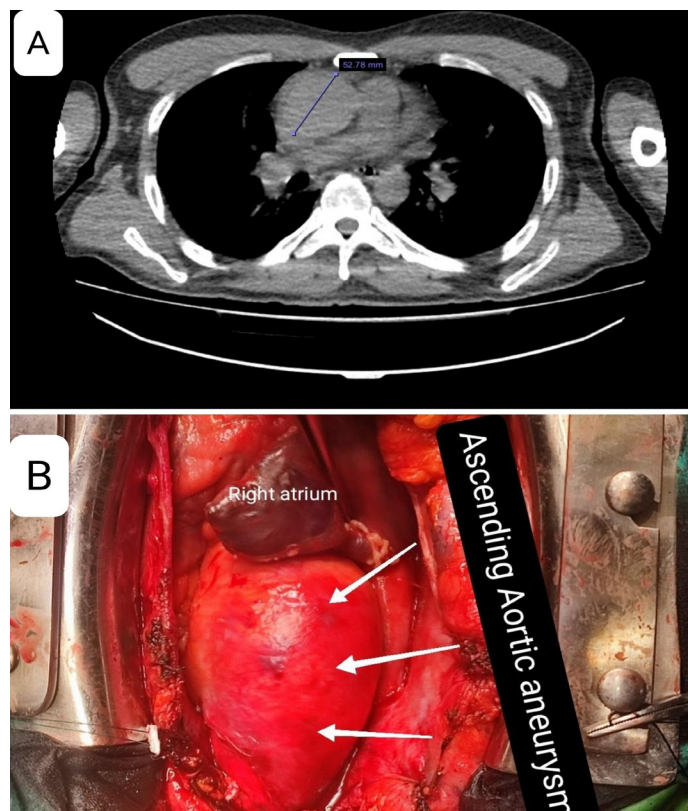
A. Preoperative computed tomographic image of the ascending aortic aneurysm. B. Intra-operative image that demonstrating an ascending aortic aneurysm
